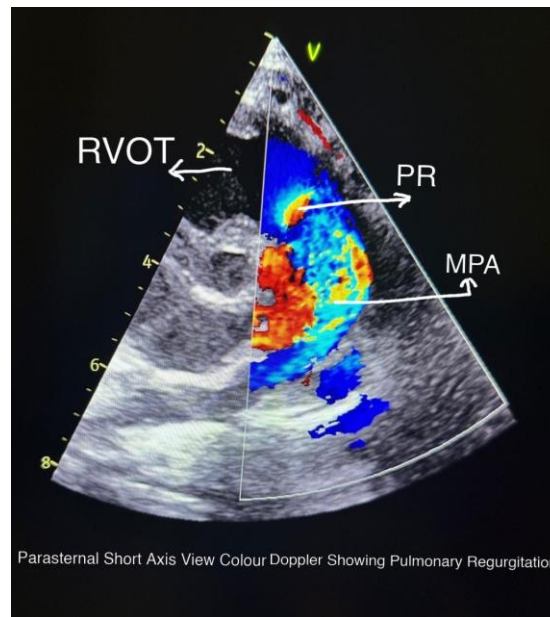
Parasternal short axis view colour doppler showing pulmonary regurgitation
